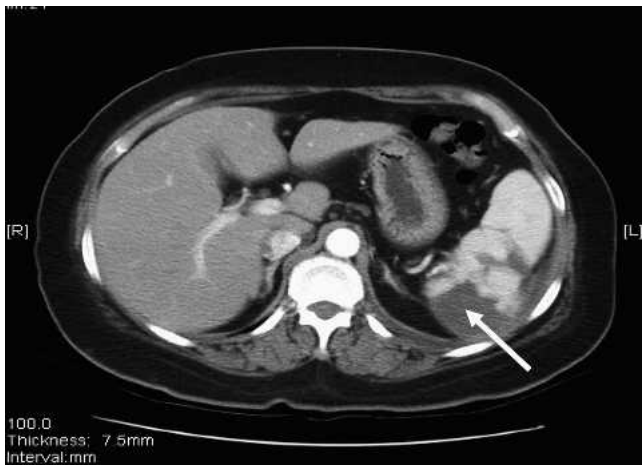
Abdominal CT shows partial infarction of the spleen (arrow) at three months after angioembolization.
